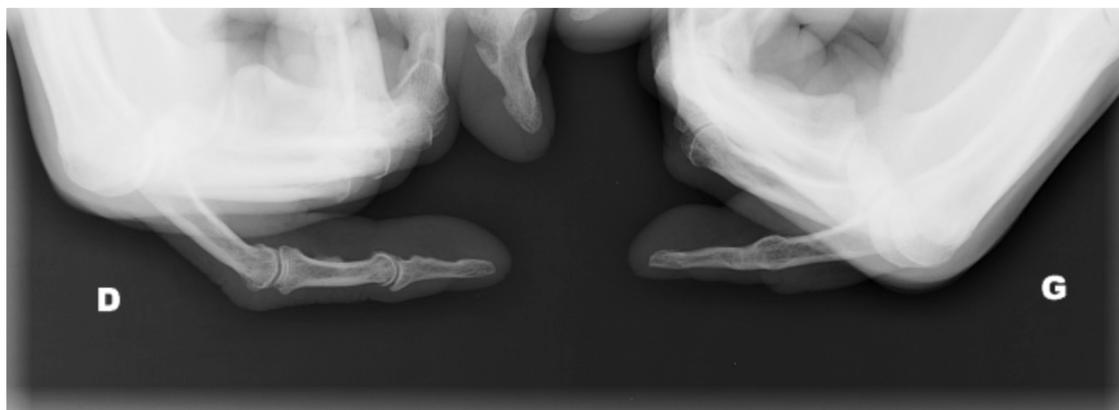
Comparative X-rays showing that fusion is achieved, and the little finger can be extended.
